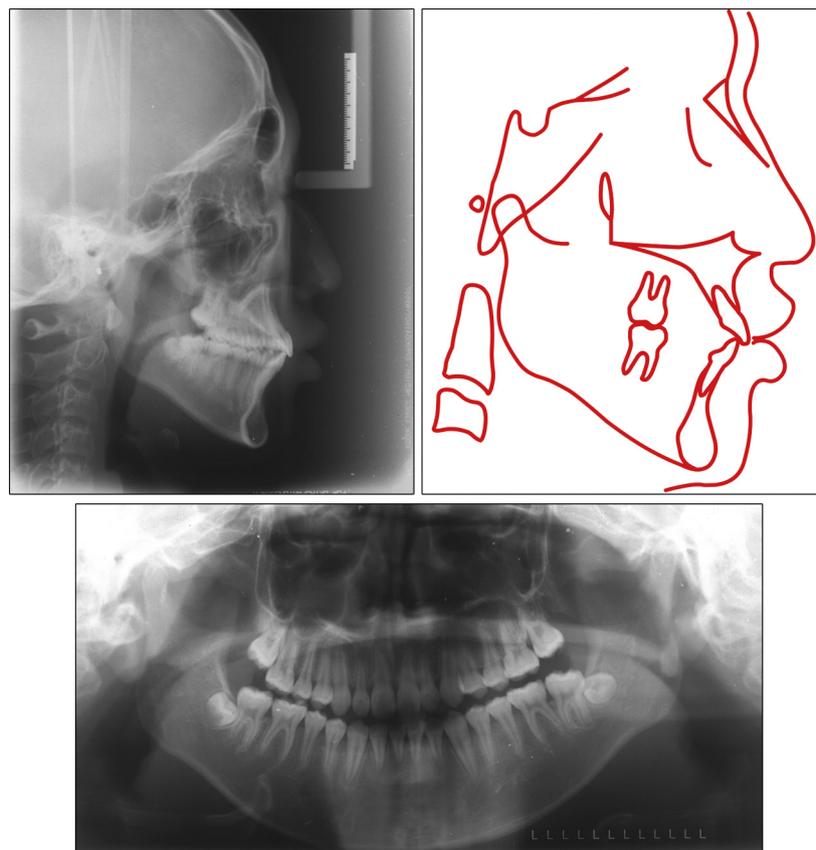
Posttreatment lateral cephalogram and tracing and panoramic radiograph.
